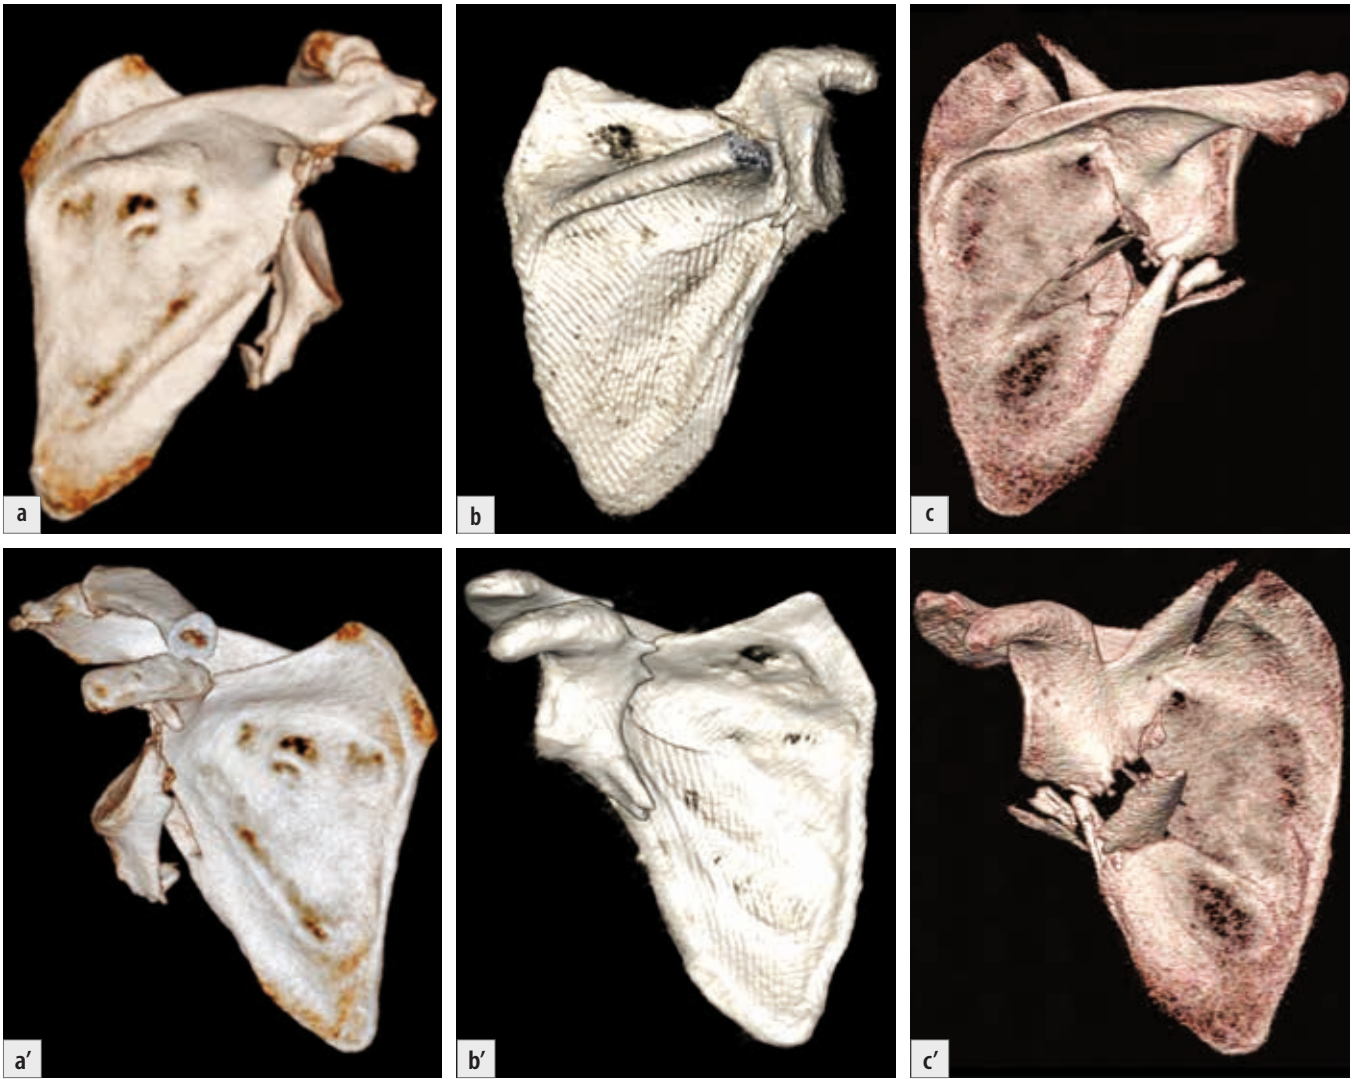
Scapular neck fractures – anterior and posterior views, on 3D CT reconstructions: a) anatomical neck fracture; b) surgical neck fracture (posterior view with subtraction of the acromion); c) transspinous neck fracture.
